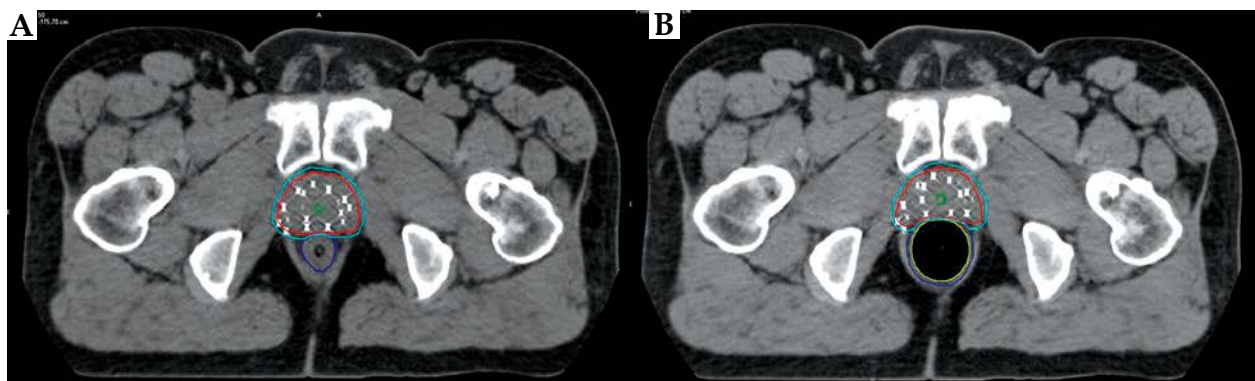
A) Computed tomography image with “empty rectum” status. B) Same patient, same slice with “full rectum” status: balloon filled with air. Note differences not only in rectum but also in prostate shape
